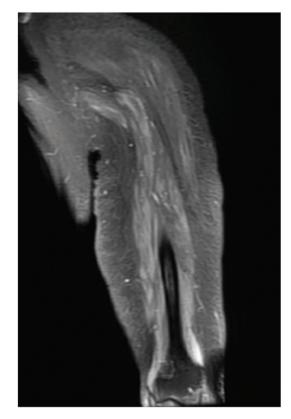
Left humerus gadolinium-enhanced fat-saturated T1weighted MRI coronal image, showing diffuse enhancement of musculature consistent with myositis.
